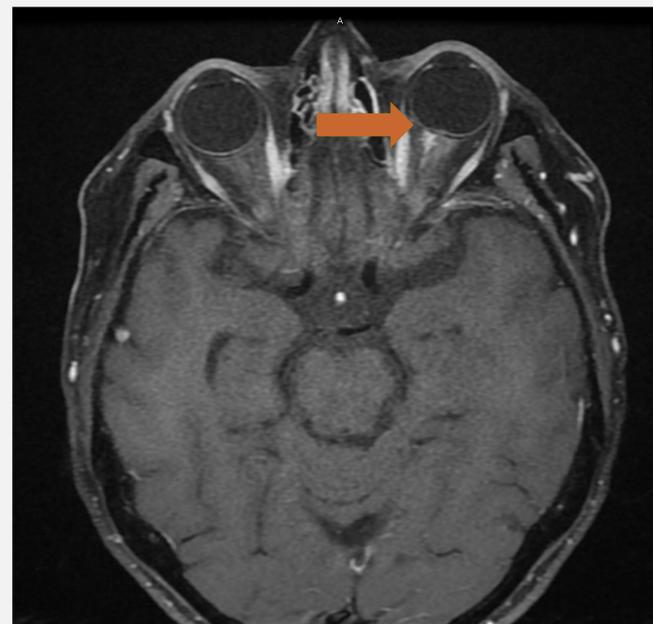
Postcontrast T1 axial fat-suppressed MRI demonstrates enhancement of the proximal left optic nerve sheath
